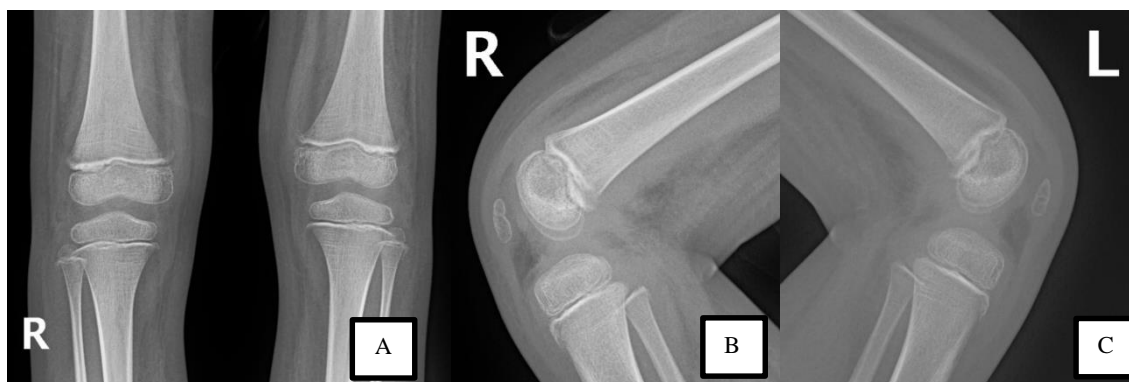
(a–c) Radiographs of the knees demonstrating generalized osteopenia, cortical thinning, dense metaphyseal bands (Frankel lines), metaphyseal corner fractures, and subepiphyseal lucencies; radiologic hallmarks of pediatric scurvy
